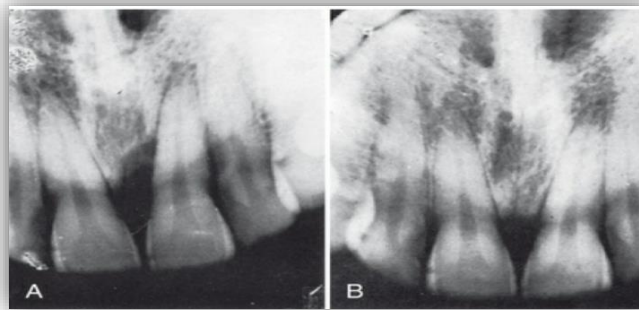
Bone regeneration after closed scaling, root planing, and curettage. (A) Before and (B) after radiographs are shown
